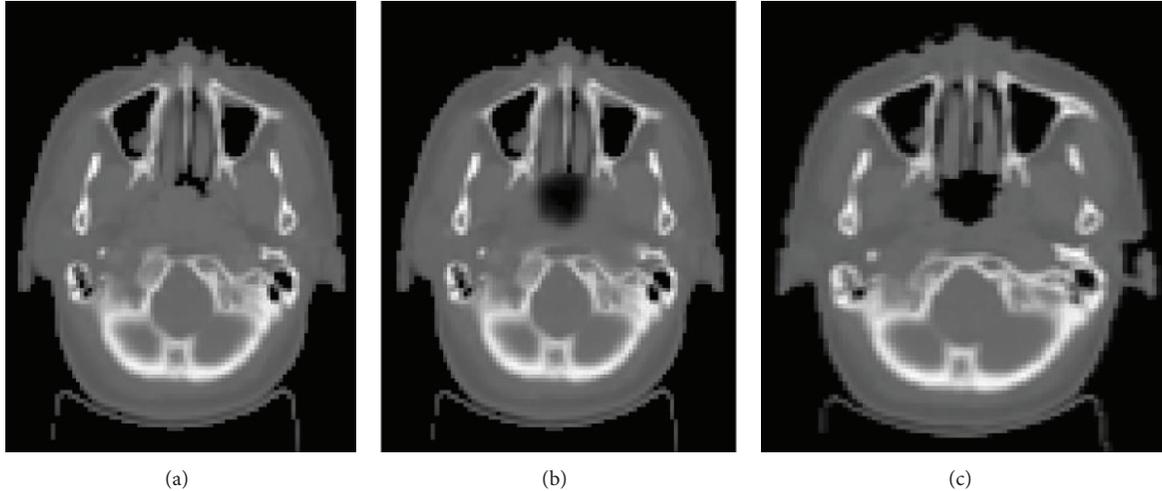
Example of intensity-modification procedure. (a) An axial slice of a planning image. (b) The same image after intensity modification. This modified planning image can be accurately registered using deformable image registration. (c) The corresponding slice from the posttreatment CT image.
